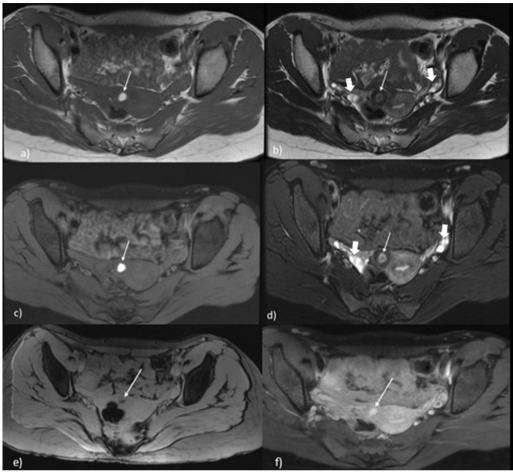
MRI pelvis of a 17-year-old female with cyclic pelvic pain. Axial T1W SE image (a) shows a round hyperintense lesion (white arrow) in the right anterolateral myometrium, at the site of attachment of round ligament. Axial T2W SE image (b) reveals a thick-walled, round lesion with hypointense wall and shading of internal contents. Uterine endometrium is seen separately from the lesion. Both ovaries are normal (short white arrows). Corresponding axial T1W FS (c) and axial T2W FS (d) show no suppression of signal on fat saturated images, suggesting blood products. Axial T2* gradient-recalled echo (GRE) image (e) shows blooming of contents, confirming bleed. Axial T1W FS post-contrast image (f) shows isoenhancement of the wall relative to the myometrium. No enhancement of the intraluminal contents seen. Imaging features are suggestive of accessory and cavitated uterine mass (ACUM)
